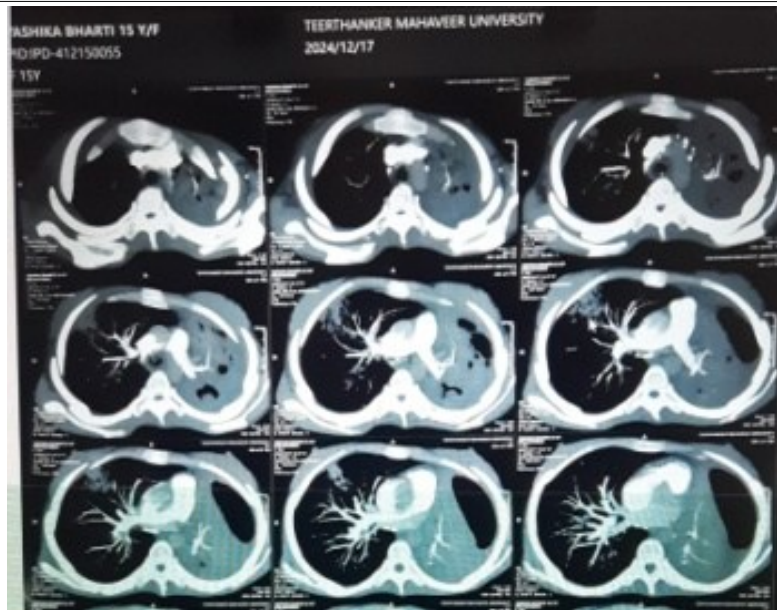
CT Pulmonary angiogram showing partial filling defects in most of the segmental branches of right lung
